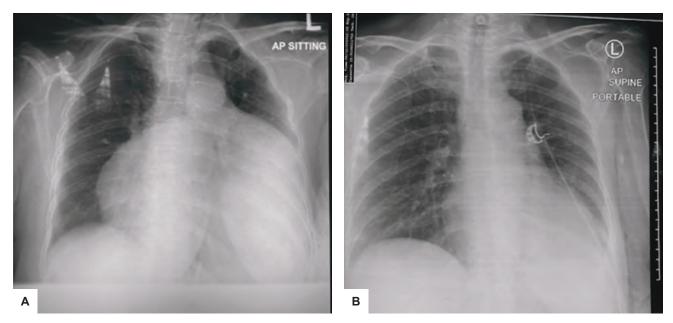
(A) Chest radiograph of Case 2 showing cardiomegaly with globular enlargement. (B) Chest radiograph post pericardiocentesis showing resolution of pericardial effusion.
